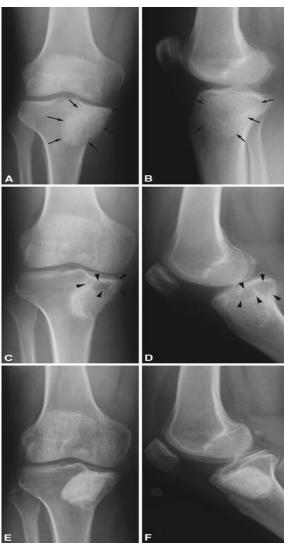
(A) AP and (B) lateral radiographs show the radiographic situation after curettage and bone grafting of the primary tumor (former tumor cavity filled with bone graft is marked by arrows). (C) AP and (D) lateral radiographs show regions of osteolysis of the proximal tibia that indicate local recurrence (osteolytic lesions marked by arrowheads). (E) AP and (F) lateral radiographs show the tibia after treatment of the recurrence with intralesional curettage, PMMA void filling.⁽²⁷⁾
